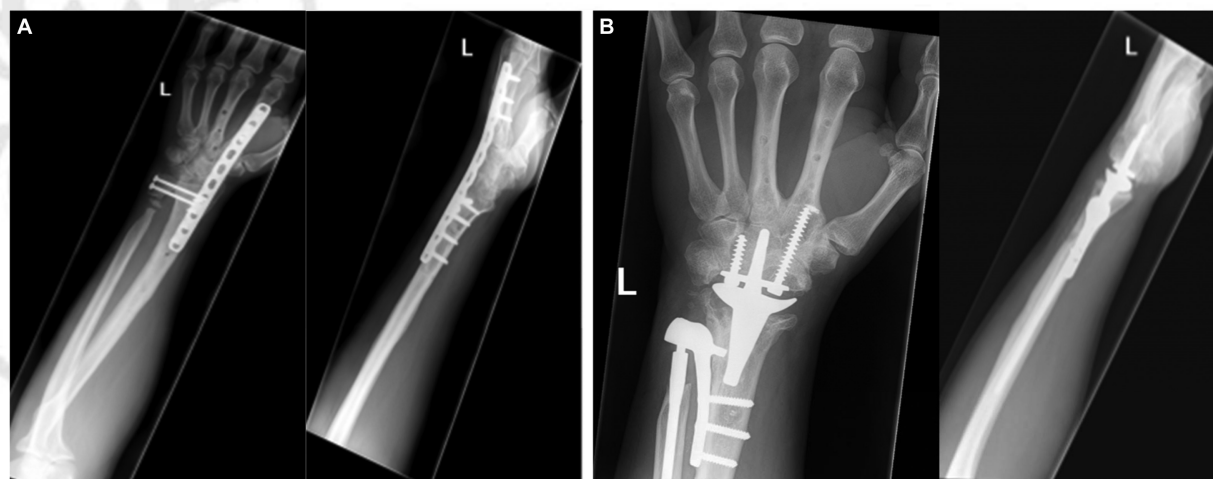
(A) Lateral and anteroposterior X-rays of case 6 before insertion of the Aptis distal radioulnar joint (DRUJ) and Remotion implant. (B) Lateral and anteroposterior X-rays of case 6 after insertion of the Aptis DRUJ and Remotion implant. Note periprosthetic osteolysis at the Remotion implant near the joint and the ulnar screw was not optimally placed.
